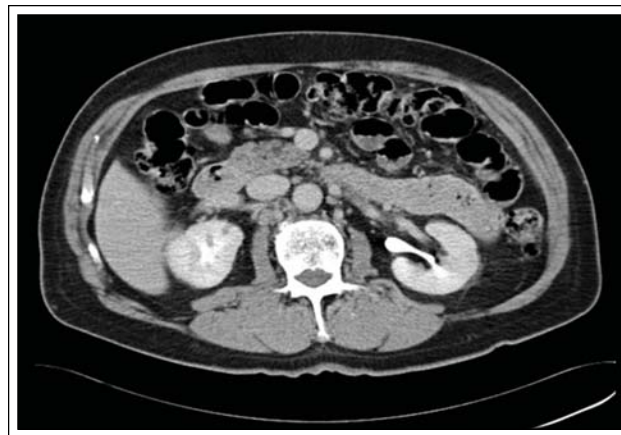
Follow-up CT scan following INH therapy. CT scan acquired 5 months from Figure 1 CT scan demonstrates almost complete resolution of renal mass.
